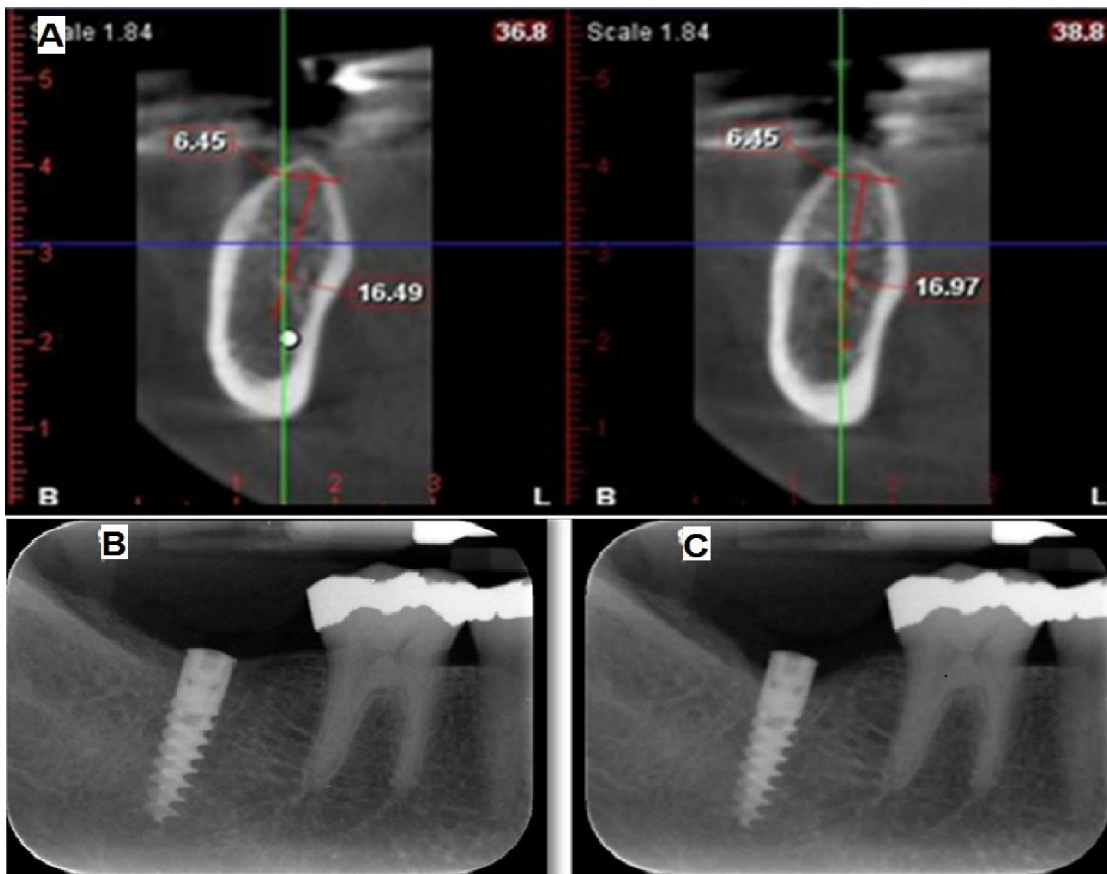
A) Preoperative CBCT for third dimension analysis, B) Digital periapical radiograph for the same case just after implant insertion (baseline) and C) Digital periapical radiograph for the same patient at six months showing the standardized view.
